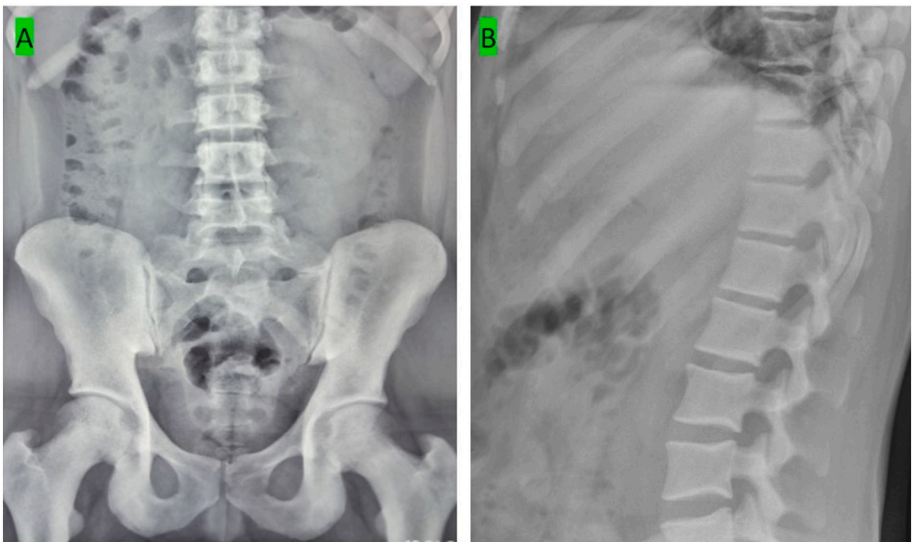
X-ray anteroposterior view of pelvis with both hips and lateral view of dorso-lumbar spine reveals generalized increased bone density uniformly involving all the visualized bones.
